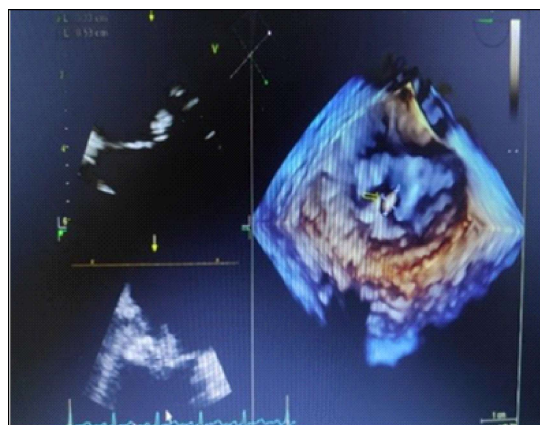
Vegetation in Mitral Valve – Transesophageal Echocardiogram (TEE) image.
